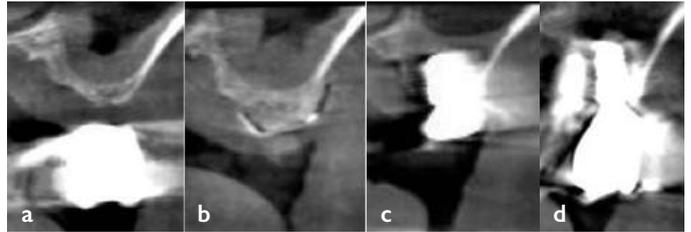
CT scans taken before ponc removal, after GBR, after implant placement, and after completing the final restoration at tooth #26, respectively
